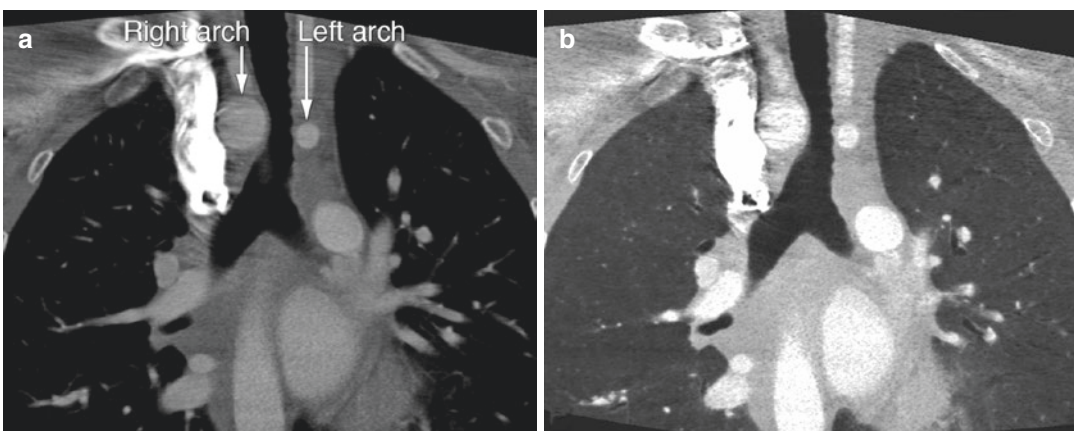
Tracheal narrowing due to double-aortic arch. CT angiography in a 14-year-old male patient with double-aortic arch and recurrent pulmonary infections, coronal reconstructions. (a) Soft-tissue setting showing
